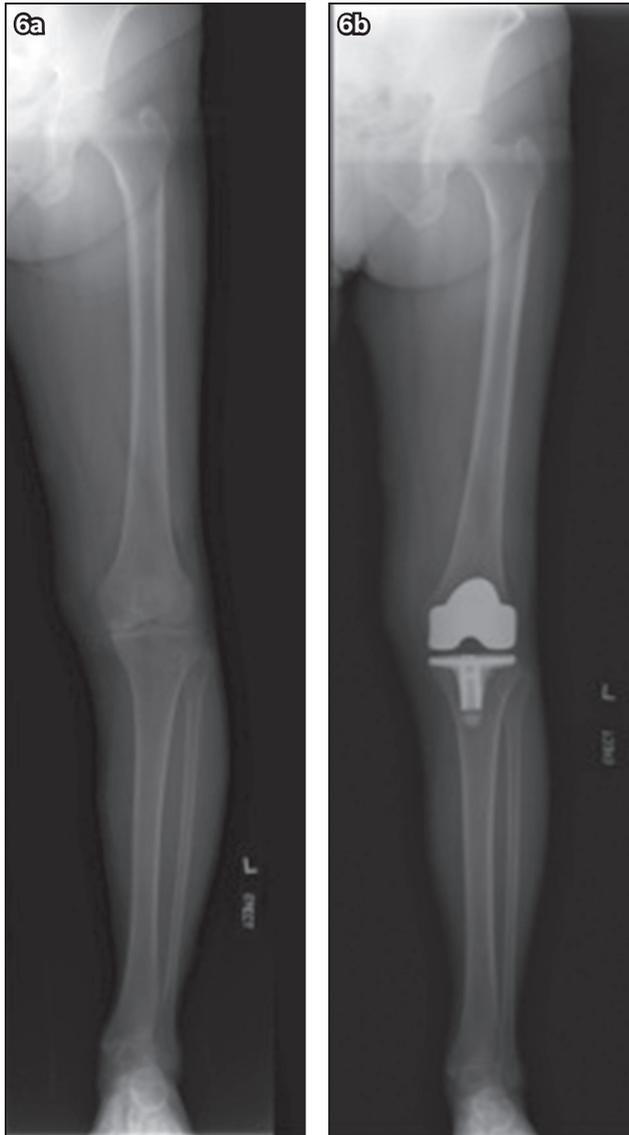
Long-leg radiographs show the leg of a patient (a) before and (b) after robot-assisted total knee arthroplasty using ROBODOC®.
